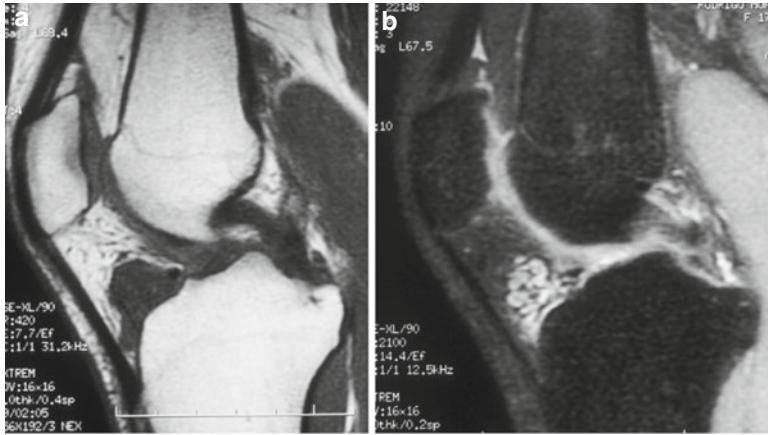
MRI. Sagittal plane FSE T1W, showing a rounded lesion involving the infrapatellar Hoffa's fat pad, isointense with skeletal muscle, displacing the intermeniscal ligament but without affecting either bone or the patellar tendon (a). Oblique sagittal plane FSE PDW with Fat
